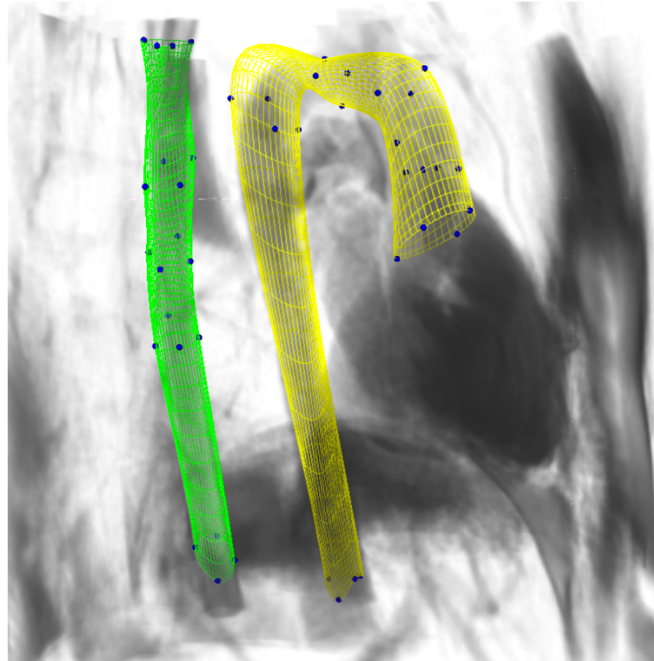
Segmentation of the spinal cord (green) and aorta (yellow) on MRI data from (Gupta et al., 2017). Adapted from (Gupta et al., 2017).
